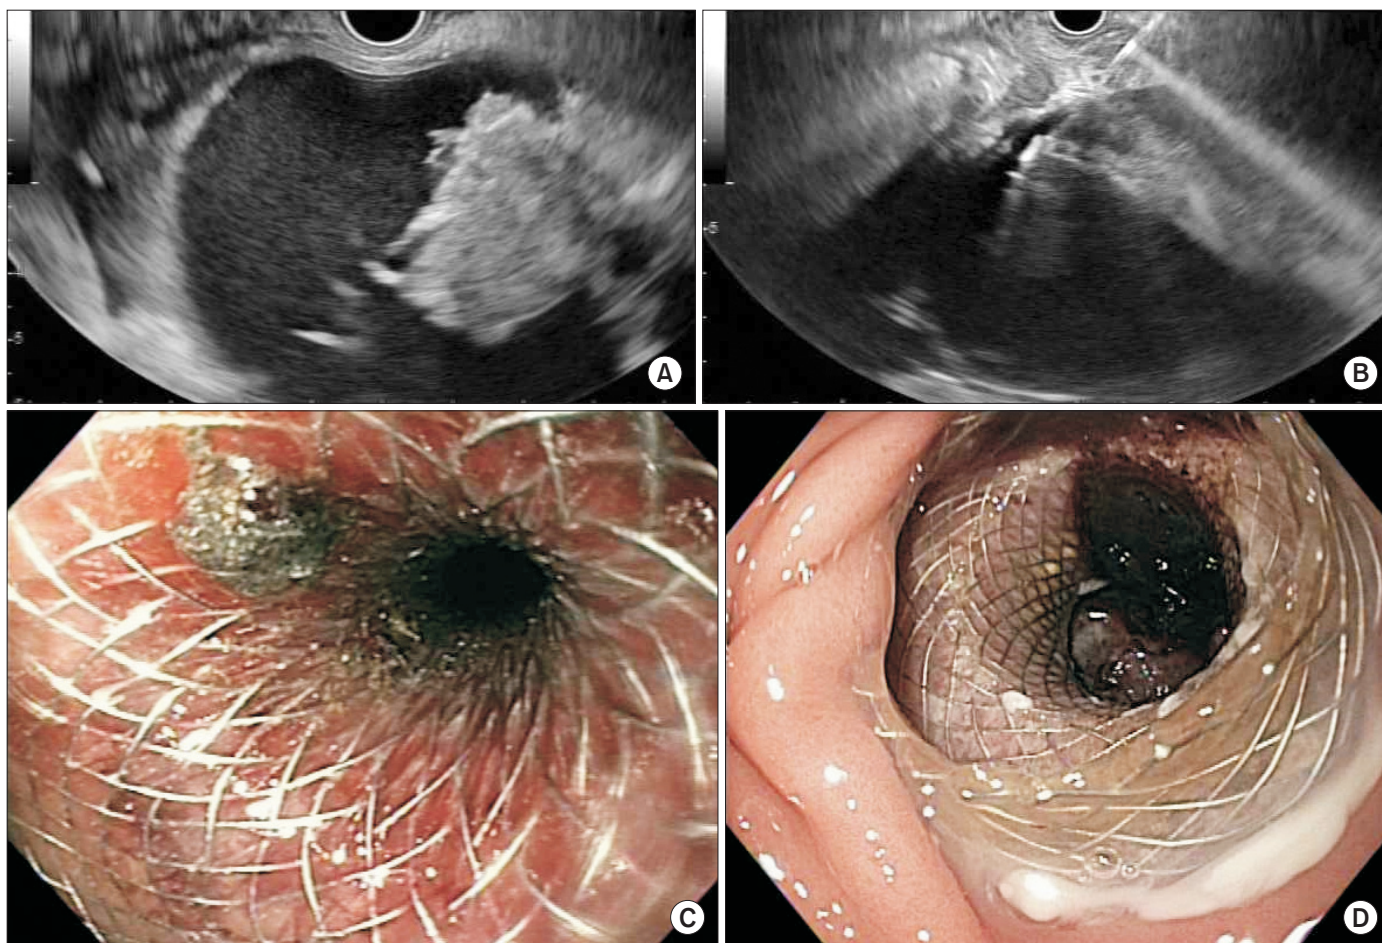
Lumen-apposing metal stents for walled off pancreatic necrosis access, drainage, and debridement. (A) Endoscopic ultrasound (EUS) image (7.5 MHz) of a large pancreatic fluid collection (PFC) with solid and liquid contents. (B) EUS image (7.5 MHz) of the AXIOS stent (Xlumena Inc.) on its delivery catheter before deployment. (C) AXIOS stent immediately after deployment. Note some solid necrotic debris in stent. (D) AXIOS stent seen 2 weeks after placement. Note direct view into the PFC cavity, where necrosectomy was then performed.
